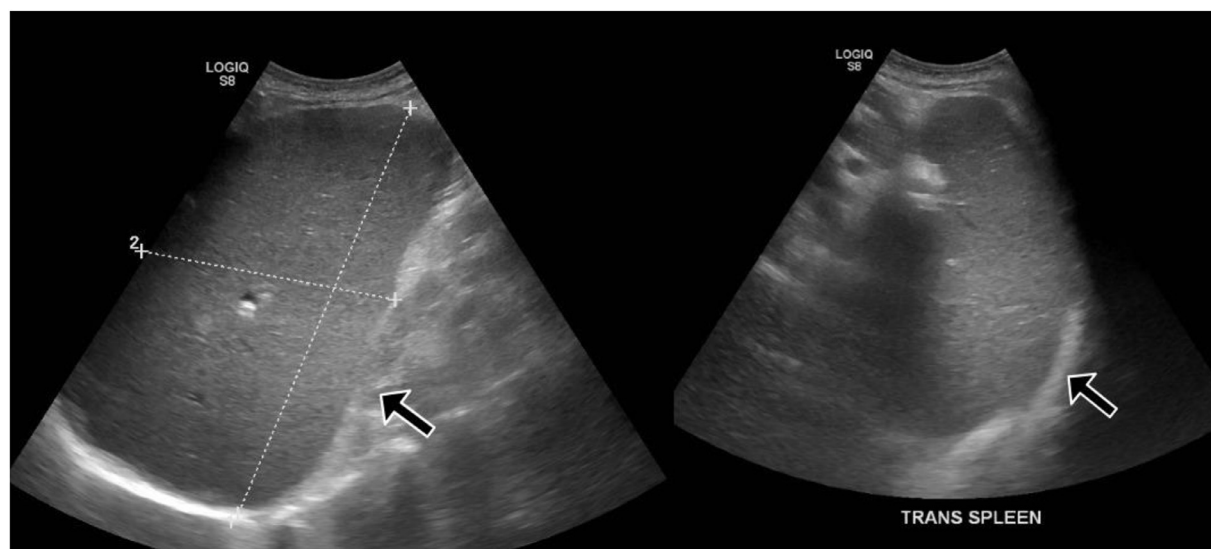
Ultrasound of the abdomen showing enlarged spleen measuring 21 x 12.5 x 8.6 cm which corresponds to volume of 1196 cc.
